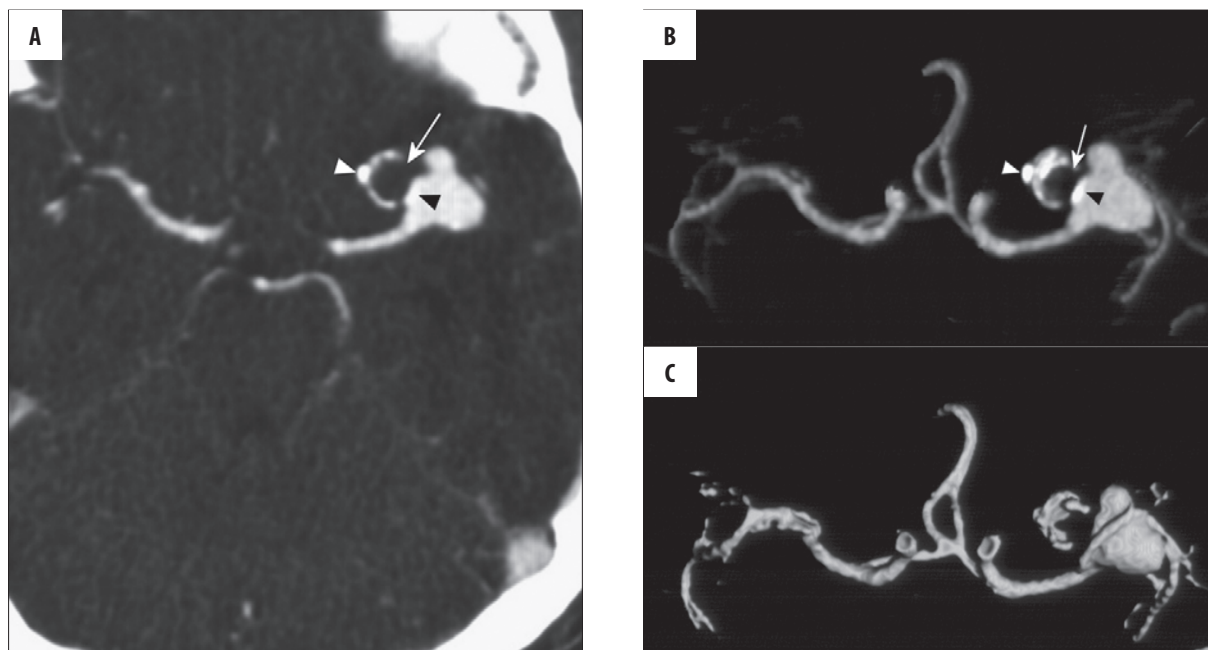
CTA: source image (A), MIP (B), and SSD (C) reconstructions. Large partially thrombosed (arrow) and calcified (arrow heads) aneurysm at the bifurcation of the left MCA. Thrombosis and calcifications can be best assessed on source and MIP images, while SSD reconstruction provides a good evaluation of the relationship between the aneurysm and the adjacent vessels.
